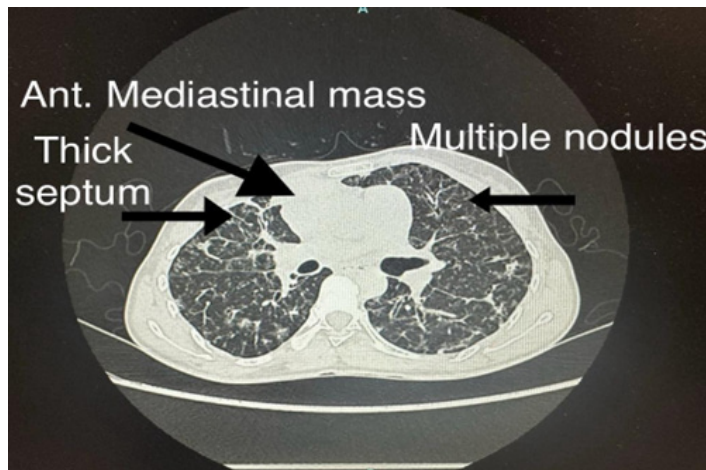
HRCT of the chest revealing extensive septal thickening with nodules
